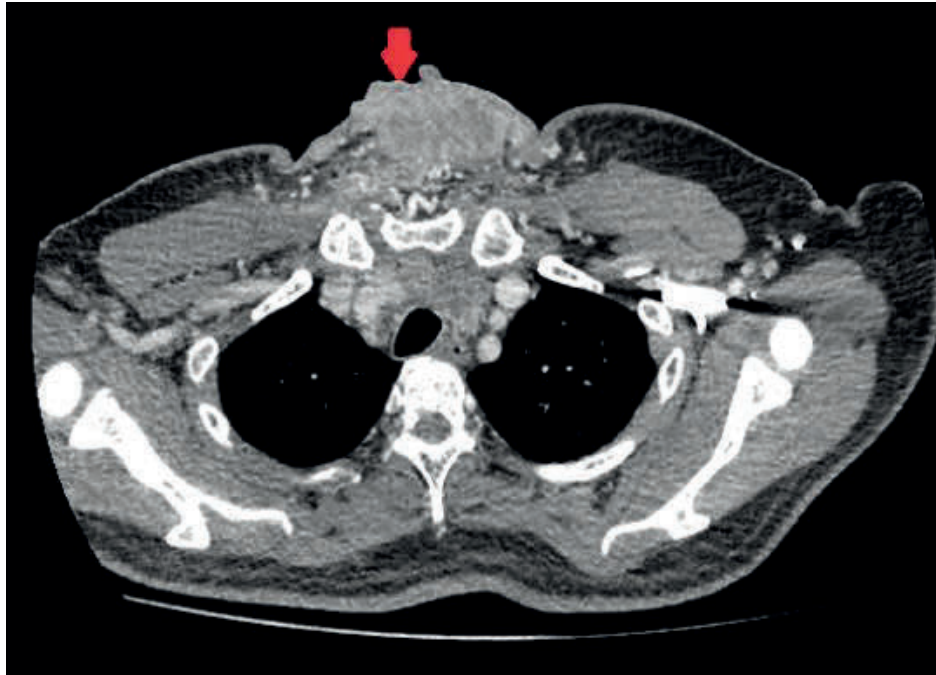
Axial cut of contrasted CT scan of neck showing a heterogenous neck mass with irregular nodular surface with skin invasion (red arrow).
